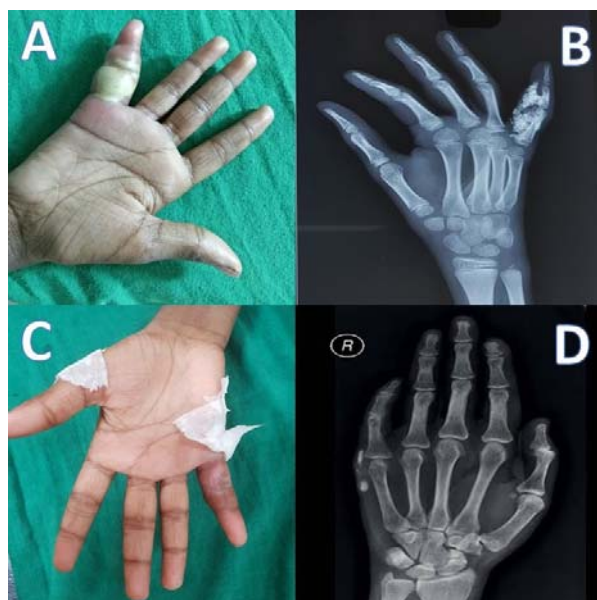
(a) Calcinosis in the little finger before treatment; (b) X-ray hand showing calcinosis before treatment; (c) clinical resolution of calcinosis after pamidronate; and (d) radiological resolution after pamidronate
